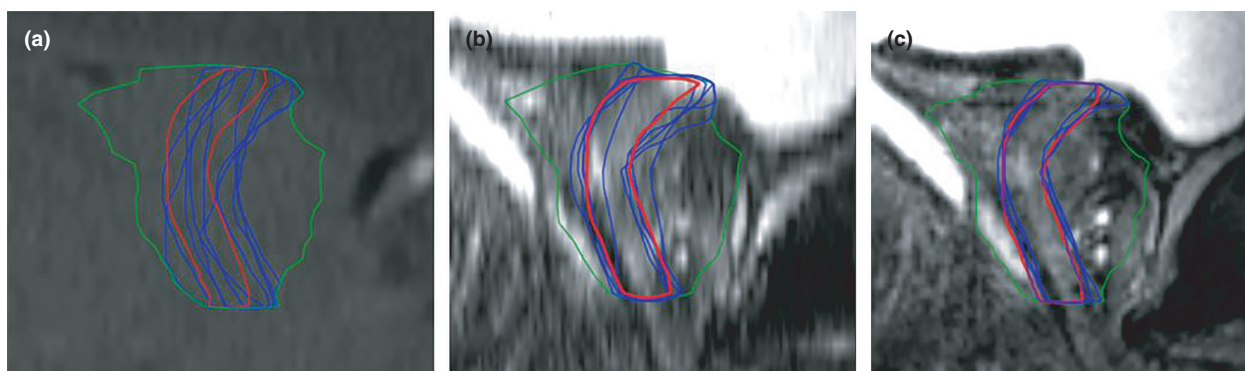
Sagittal example of one patient data set with observer urethra PRV contours (blue) and reference contour (red) for CT (A), T2 TSE (B) and T2 SPACE (C).
